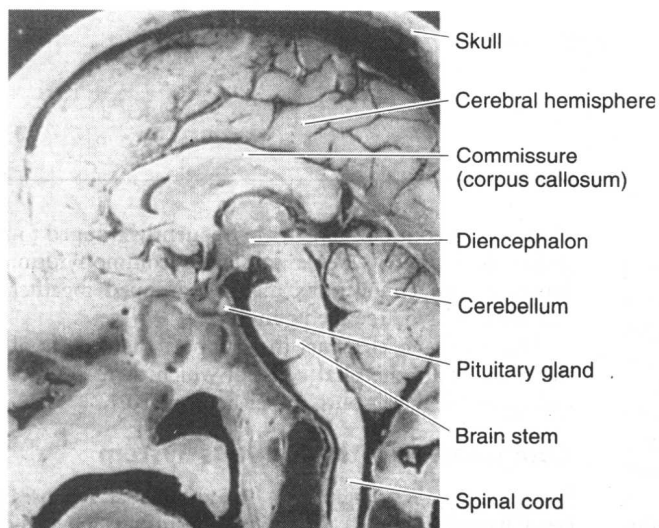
Photograph of a midsagittal section through the head and upper neck, showing the major divisions of the central nervous system. (Reproduced, with permission, from deGroot J: *Correlative Neuroanatomy of Computed Tomography and Magnetic Resonance Imagery*. Lea & Febiger, 1984.)
